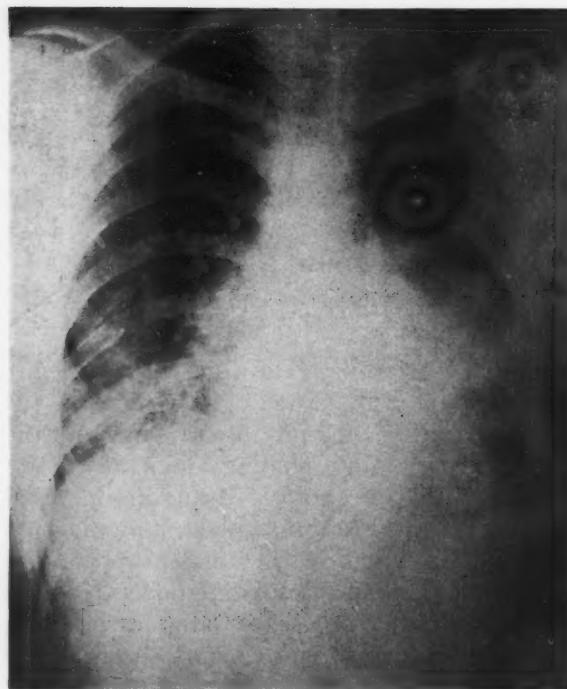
X-ray of chest. The lower lobes are reduced in size and show a "honeycomb" pattern. There is an increase in linear and nodular markings. A density is seen in the region of the lingula with enlargement of lymph nodes in the left lung root, suggesting a tumor in that area.
